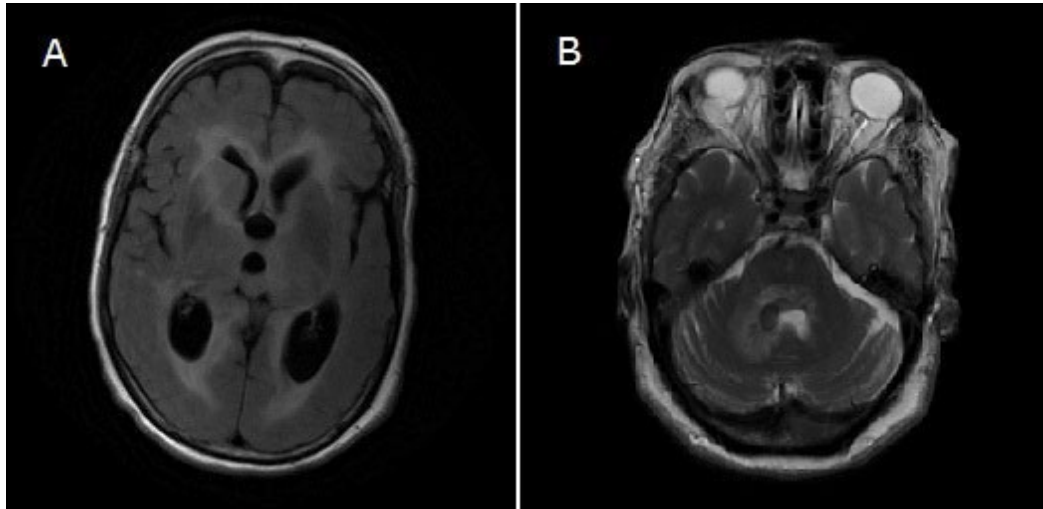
MRI shows subependymal infiltrative mass around the both lateral ventricles extending to pineal gland, pons and midbrain with enhancement and restriction in favor of PCNSL
